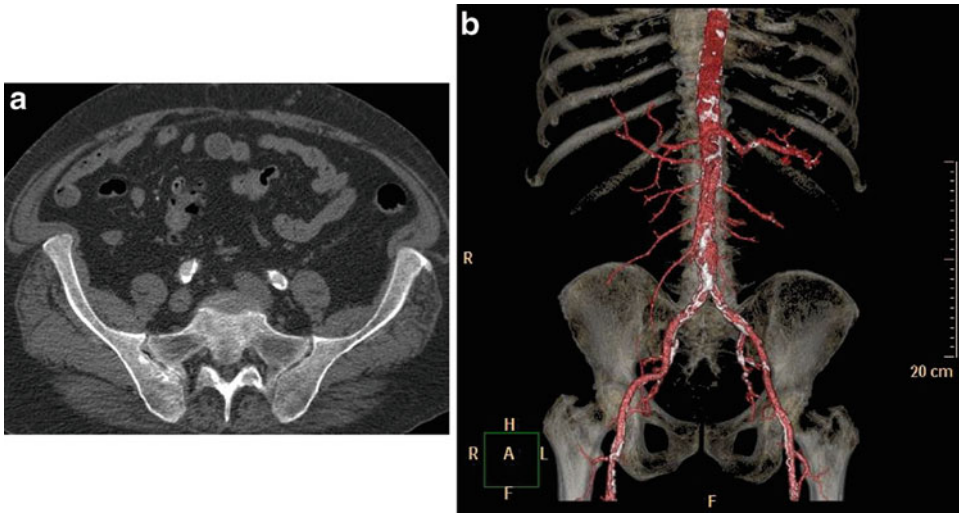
CT and CTA in transplant recipient candidates. (a) The axial image from a CTA shows heavy atherosclerotic calcification of the common iliac arteries (*arrows*). (b)
